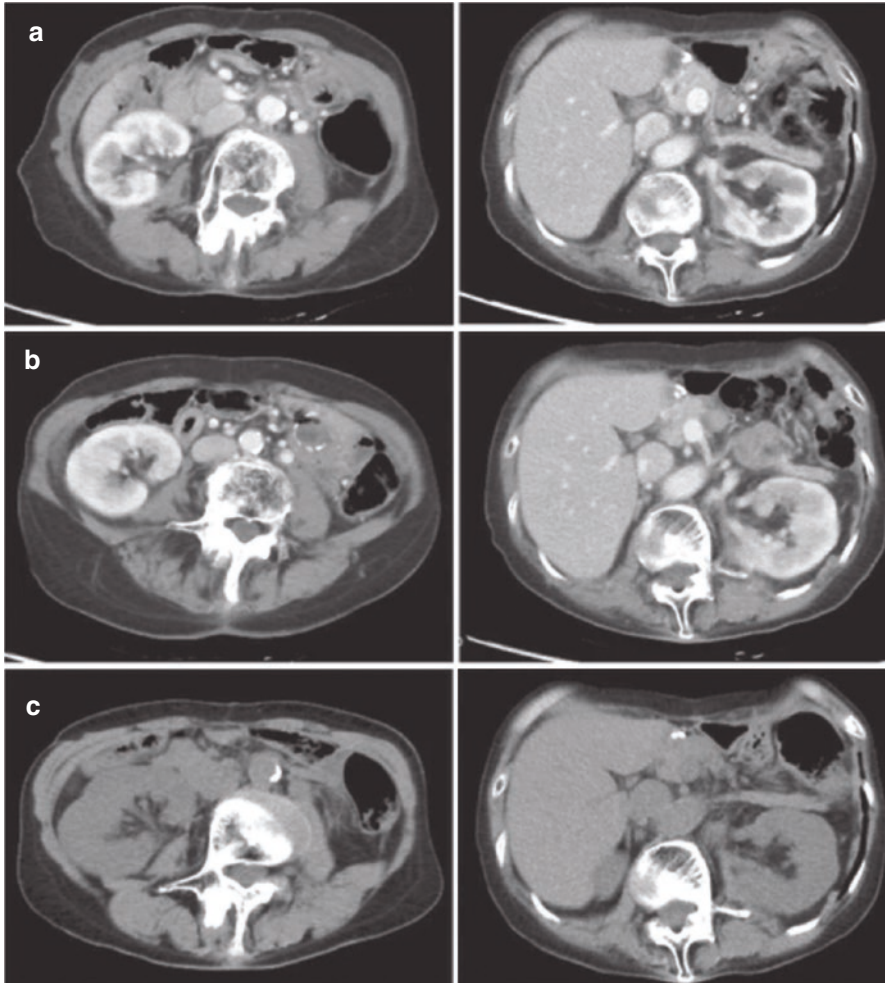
Computed tomography images of kidneys in patient with acute tubulointerstitial nephritis associated with immune checkpoint inhibitor therapy. Three rows display images after 34 cycles of therapy (a), 37 cycles of therapy (b), and 1 week after completion of 38 cycles of therapy (c). With continued therapy, the bilateral kidneys show progressive enlargement in size. (Reference: Nakatani Y, Kawakami H, Ichikawa M, Yamamoto S, Otsuka Y, Mashiko A, Takashima Y, Ito A, Nakagawa K, Arima S. Nivolumab-induced acute granulomatous tubulointerstitial nephritis in a patient with gastric cancer. *Invest New Drugs*. 2018;36:726–31. Springer Nature publication – agreement submitted and receipt available on request)
